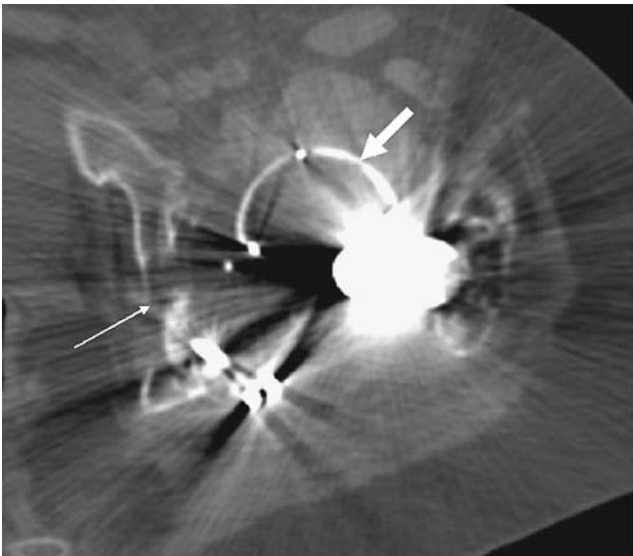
43-year-old female status post left total-hip arthroplasty revision and open reduction internal fixation for acetabular fracture. Axial CT image demonstrates a fracture through the quadrilateral plate of the acetabulum (*thin arrow*) as well as dislodgement and displacement of the polyethylene liner into the anteroinferior margin of the pseudocapsule (*thick arrow*)
